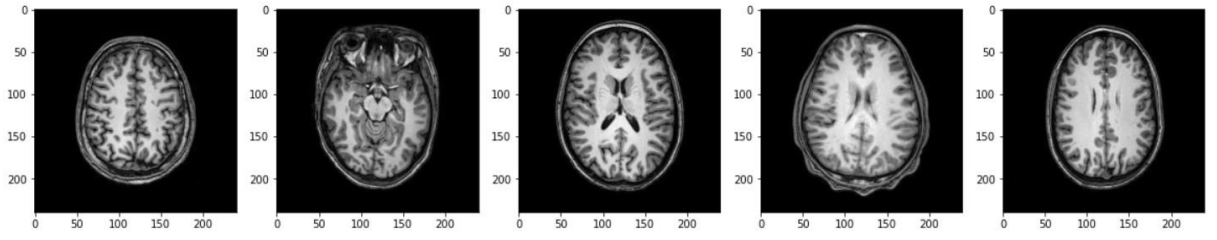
Input MRI images
